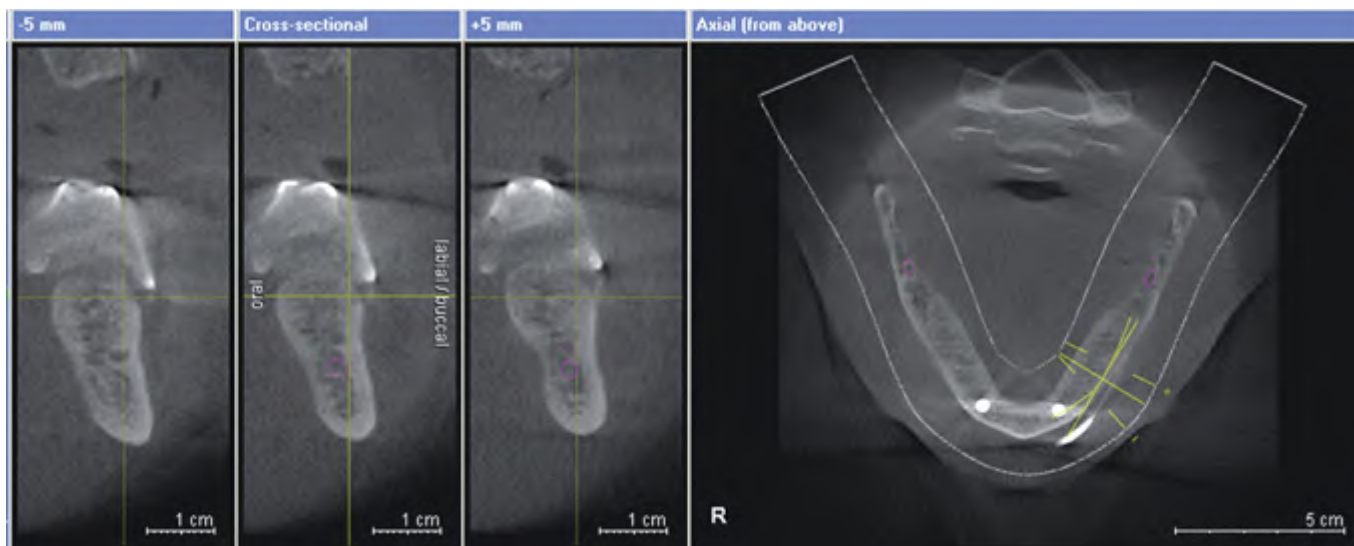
Screen shot of the left posterior mandibular segment's CT scan, with the scanning appliance in place. The location of the left inferior alveolar nerve was clearly seen (purple circle). The location of the slice was indicated by the line on the occlusal view of the mandible (right side of image).
